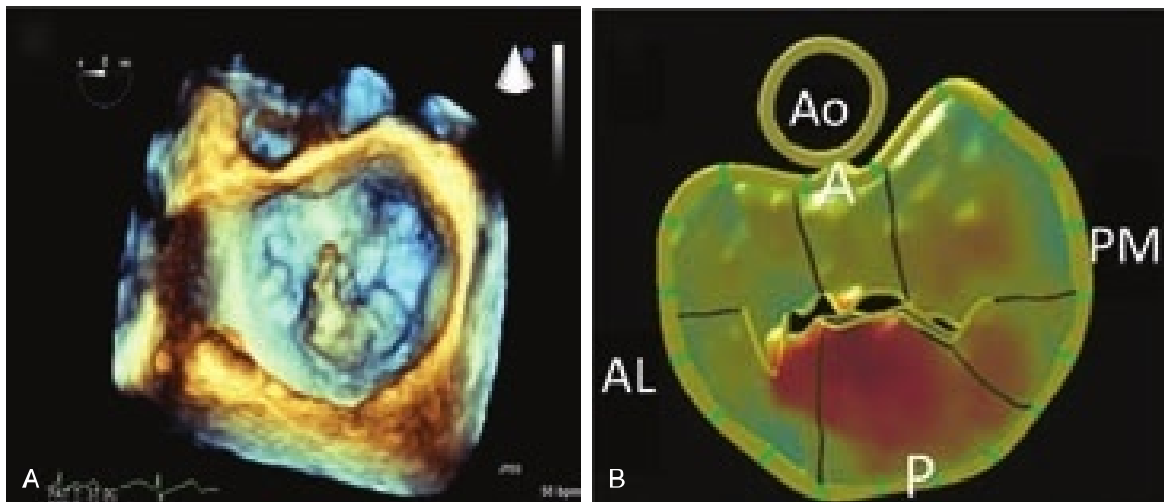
(A) Three-dimensional transesophageal echocardiography view of the mitral valve with a flail at the P2 region as seen from the “surgeons view” or “en-face view” where the valve is being viewed from the left atrial perspective with the aortic valve in the 12 o’clock position and the left atrial appendage in the 9 o’clock position. (B) Parametric model of the mitral valve depicting the P2 flail. *Ao*, Aorta; *A*, anterior; *PM*, posteromedial; *P*, posterior; *AL*, Anterolateral.
